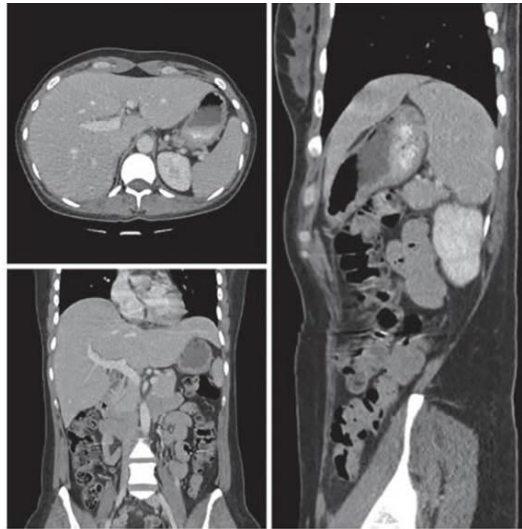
Admission CT scan, abdominal and pelvic sections, without pathological findings
